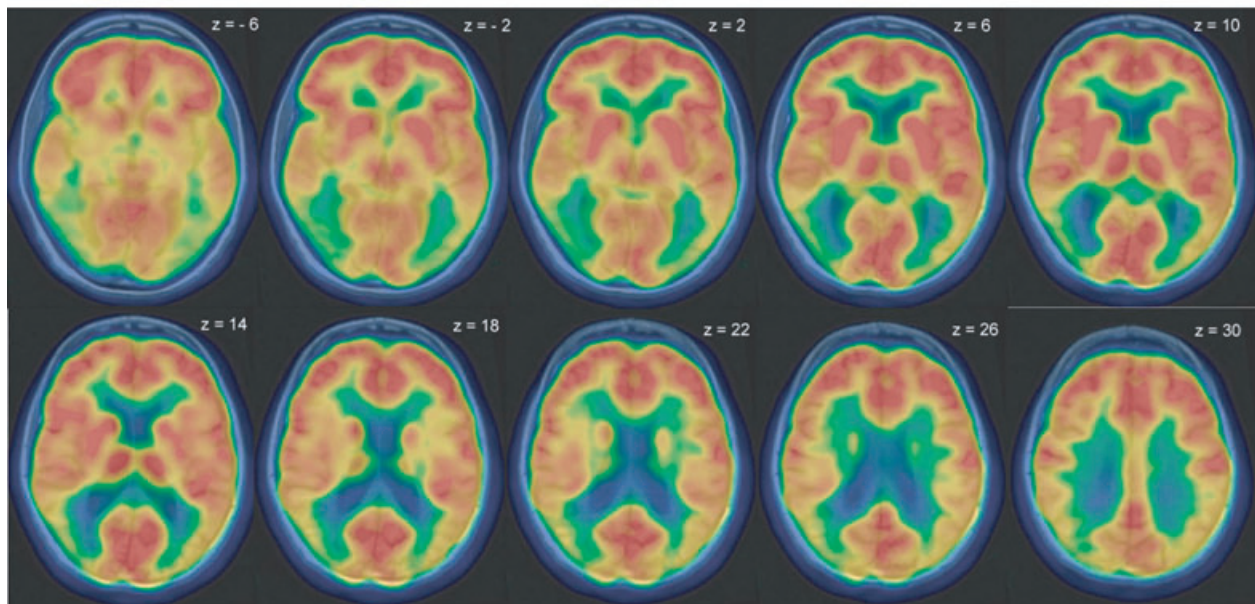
FDG-PET scans for HW and FDG-PET-CT scans for PNW overlaid with the MRI scans revealed reduced metabolism in the parieto-occipital cortex bilaterally for patients HW (top) and PNW (bottom). 18-FDG metabolism is colour coded (maximum red).
